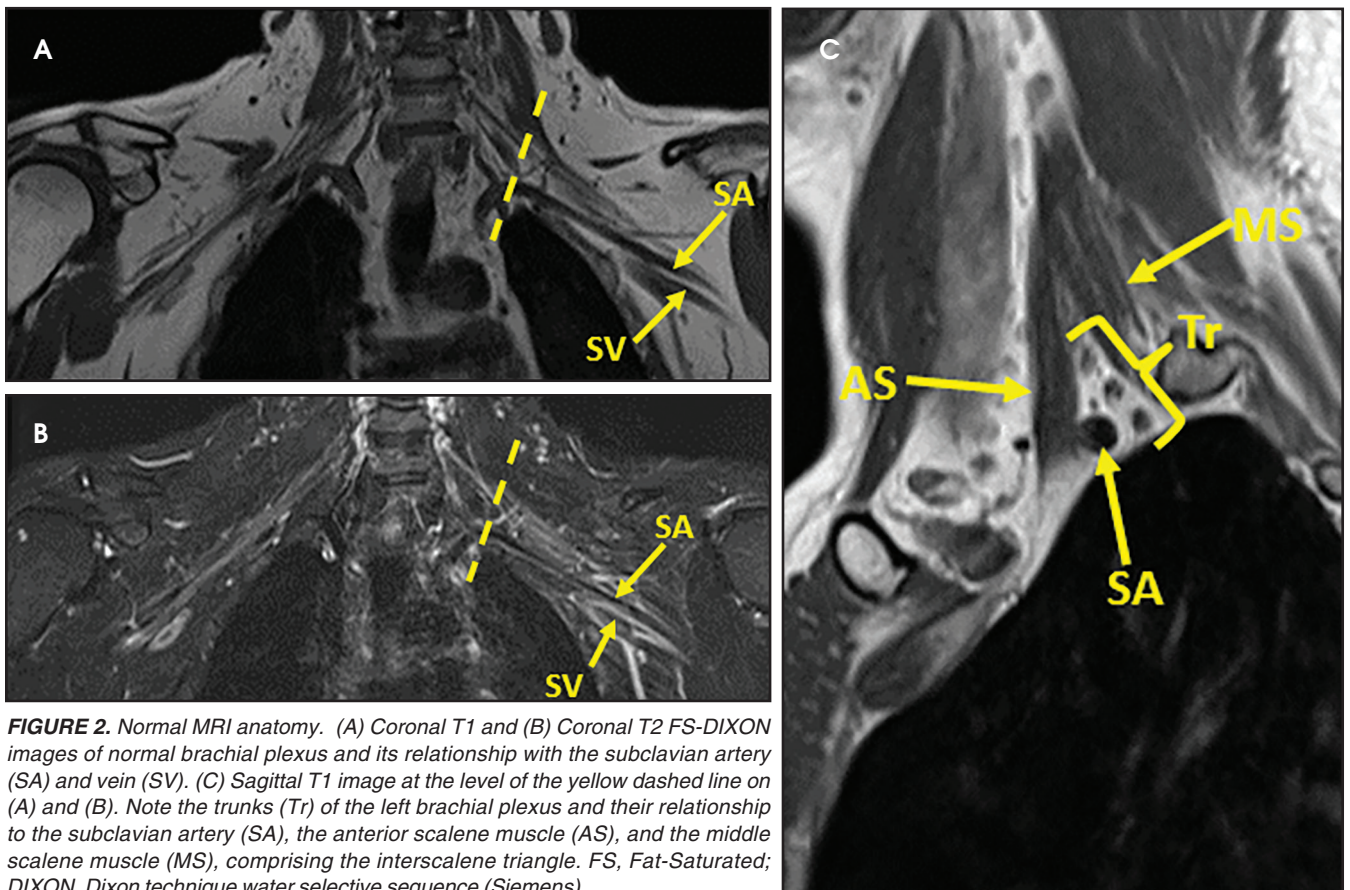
Normal MRI anatomy. (A) Coronal T1 and (B) Coronal T2 FS-DIXON images of normal brachial plexus and its relationship with the subclavian artery (SA) and vein (SV). (C) Sagittal T1 image at the level of the yellow dashed line on (A) and (B). Note the trunks (Tr) of the left brachial plexus and their relationship to the subclavian artery (SA), the anterior scalene muscle (AS), and the middle scalene muscle (MS), comprising the interscalene triangle. FS, Fat-Saturated; DIXON, Dixon technique water selective sequence (Siemens).
